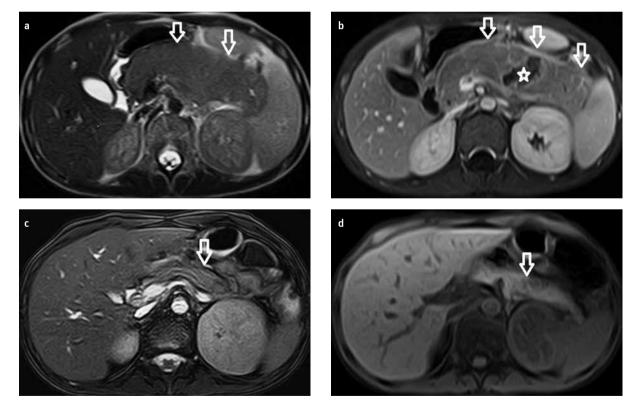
a-d. Axial T2-weighted (a) and contrast-enhanced T1-weighted magnetic resonance (MR) images (b) show a diffusely enlarged pancreas (arrows) with a central necrotic area (asterisks). After treatment, control T2- (c) and T1- (d) weighted MR images show a normal pancreas (arrow).
